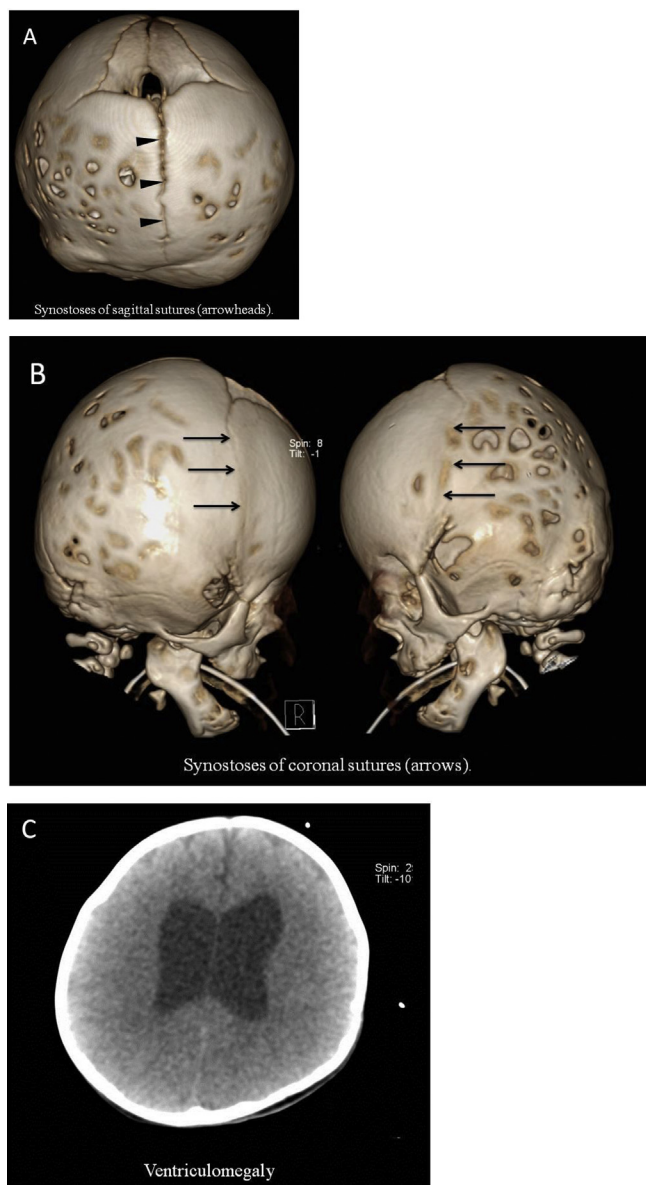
Radiographs show multisynostoses of (A) sagittal and (B) coronal sutures (arrows) and shallow orbits, and (C) ventriculomegaly.
